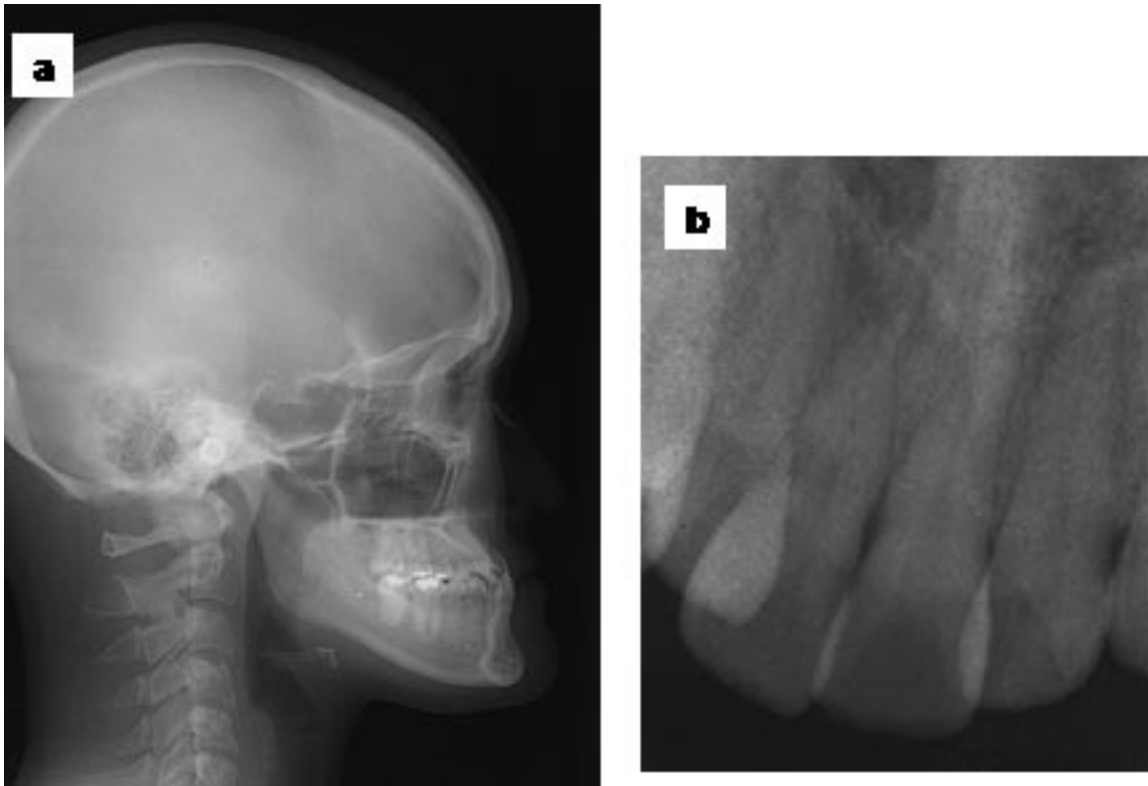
Patient 2. (a) Pretreatment cephalometric radiograph. Note the skeletal Class III profile with low mandibular plane angle. (b) Periapical radiograph of the upper incisors indicating short root and apical blunting of the central incisors.
